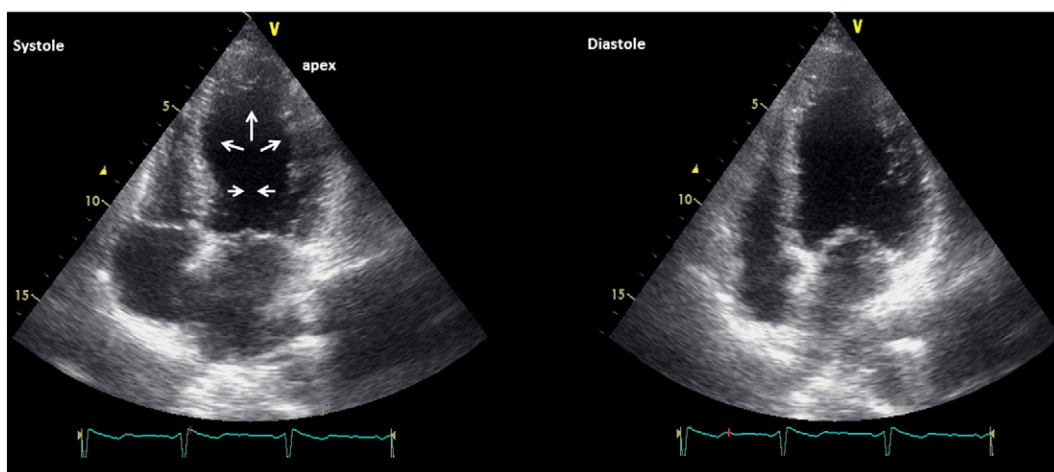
Typical echocardiographic presentation of the acute phase of tako-tsubo cardiomyopathy. A 61-year-old female presenting with acute retrosternal chest pain, mild troponin elevation and dyskinesia of the apical segments of left ventricle following deep brain stimulation for Parkinson's disease.
